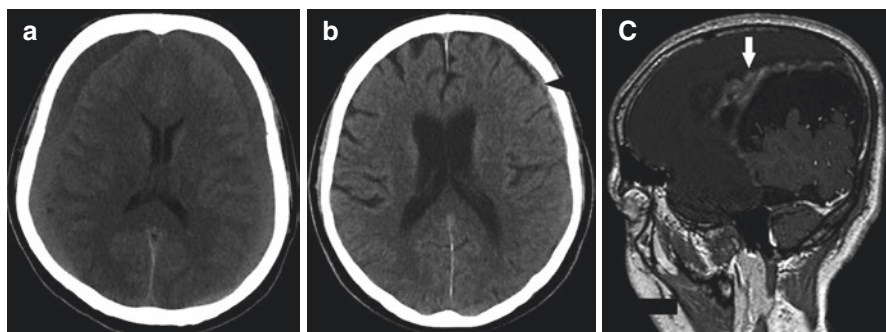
Bilateral subdural hematoma is seen on the axial CT (a) image of a 56-year-old female patient. On follow-up CT imaging taken 3 months later (b), the collection was fully regressed on the right. On the left, while hemorrhagic content is fully resorbed, linear hyperdensity due to thickening of the dura is seen. On the sagittal contrast-enhanced T1 images (c) of another 70-year-old female patient, it is noteworthy that large chronic subdural hematoma is accompanied by irregular thickening of the dura (white arrow)
